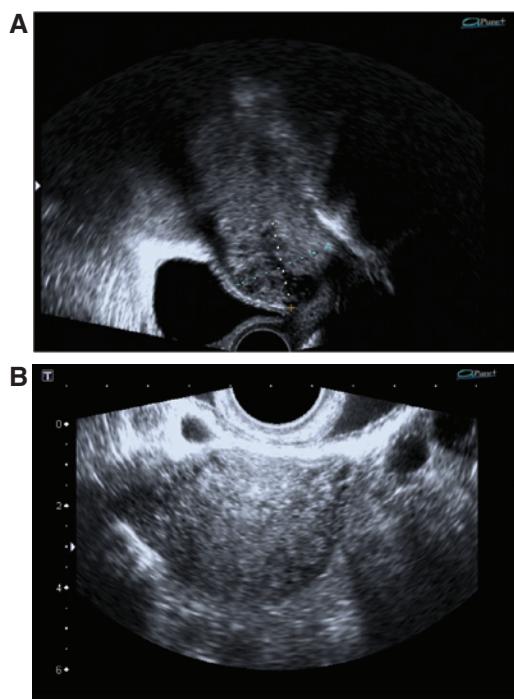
(A) Transvaginal ultrasound image depicting the heterogenous mass after combined therapies. Total hCG was 546mIU/mL in the sixth week after the initial therapy. Trophoblastic flow was still present. (B) Transvaginal ultrasound image demonstrating the resolution of the complex heterogenous mass after 8 months.
